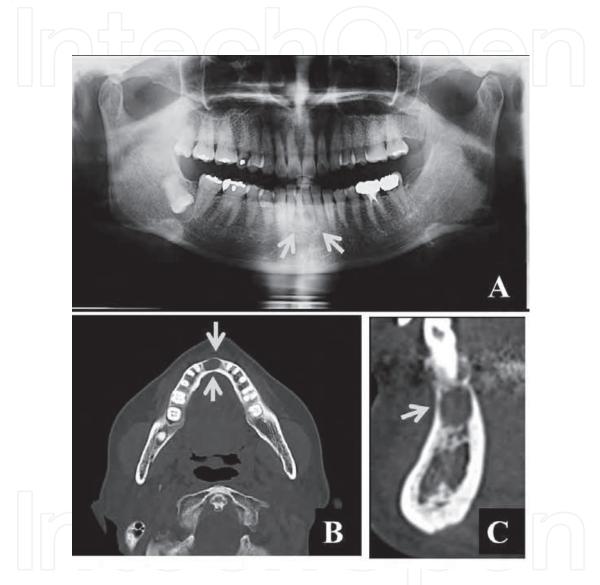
Panoramic radiograph image (A), axial (B) and sagittal (C) CT image of a simple bone cyst in the mandible (arrows).
